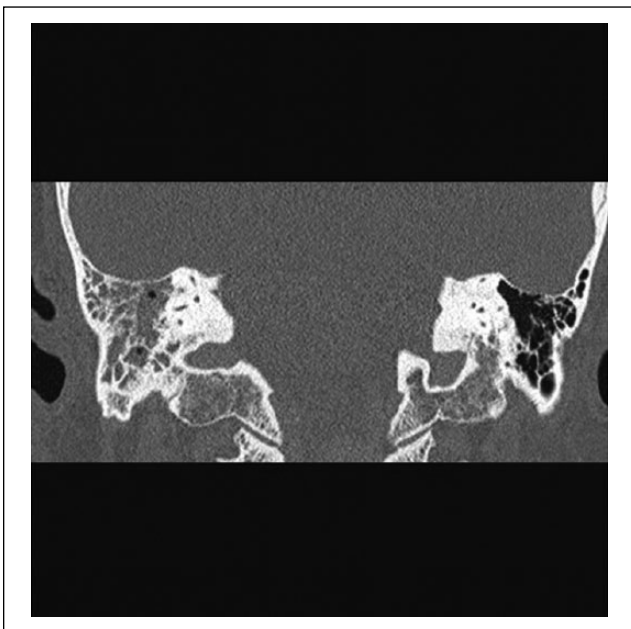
Contrasted computed tomographic coronal image of temporal bone study, demonstrating an opacified right mastoid cavity.
